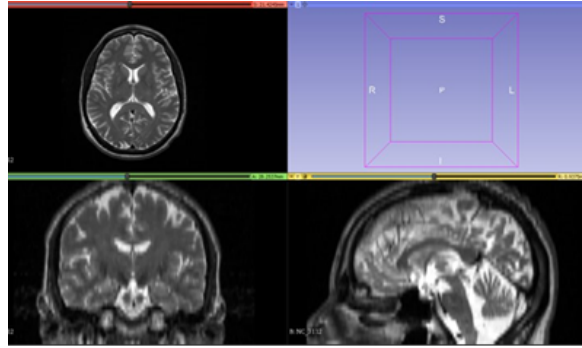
3 planes of MRI a) Axial b) Sagittal c) Coronal (clockwise direction)
